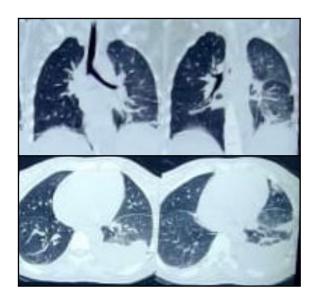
HRCT thorax showing ground glass opacities in lung parenchyma
